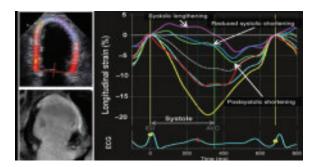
Steps involved in speckle-tracking echocardiography. ¹⁶ A. The endocardial border is manually traced in the end systolic frame. The automated software creates a region-of-interest that includes the entire myocardial thickness. B. The operator is prompted to review and approve the adequacy of tracking for each segment. C. The final strain curves. Color coded curves depict segmental strain whereas the dotted white curve depicts the average strain. The lower left corner shows the parametric image, displaying the timing and the magnitude of segmental longitudinal strain.
